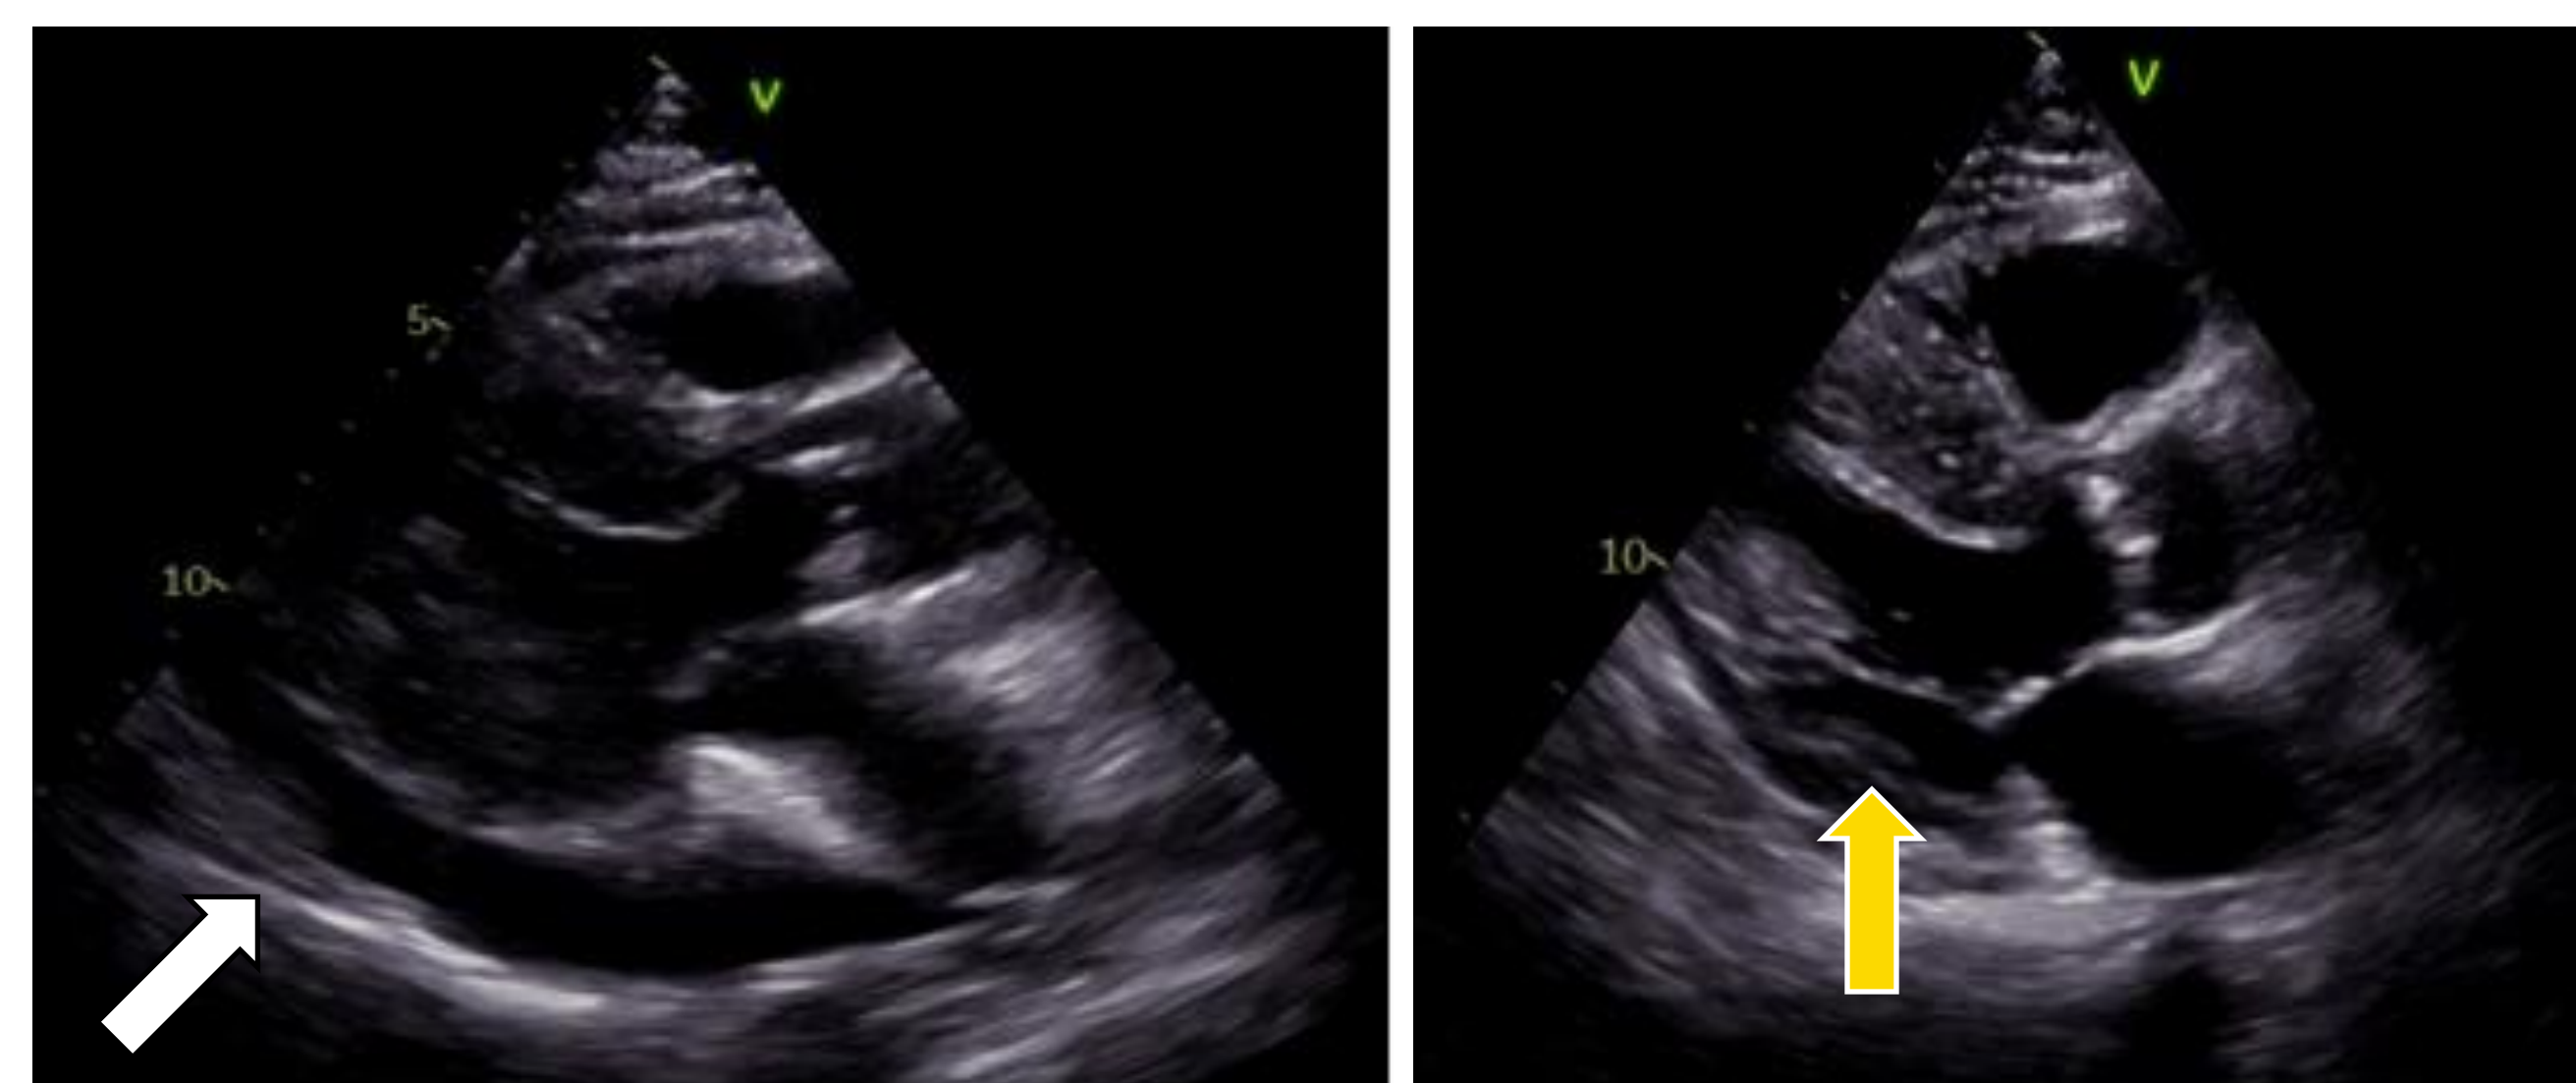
Echocardiography
